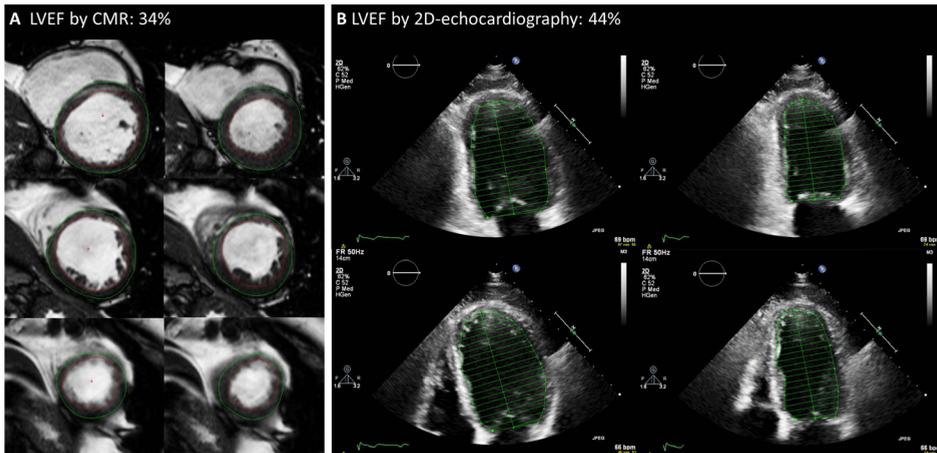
A 67-year old patient with ischemic cardiomyopathy who was screened for ICD implantation for primary prevention of sudden cardiac death. No arrhythmias were documented and the patient did not show signs of heart failure. Both 2D echocardiography and CMR were performed, which yielded a difference in LVEF of ten percentage points (44 vs. 34%, respectively). Based on echocardiographic analysis, ICD implantation should not have been performed, yet CMR drove the decision to implant the device. To date, two years after implantation, no ventricular arrhythmic events have occurred. Reprint with permission from Rijnierse et al.²⁶
